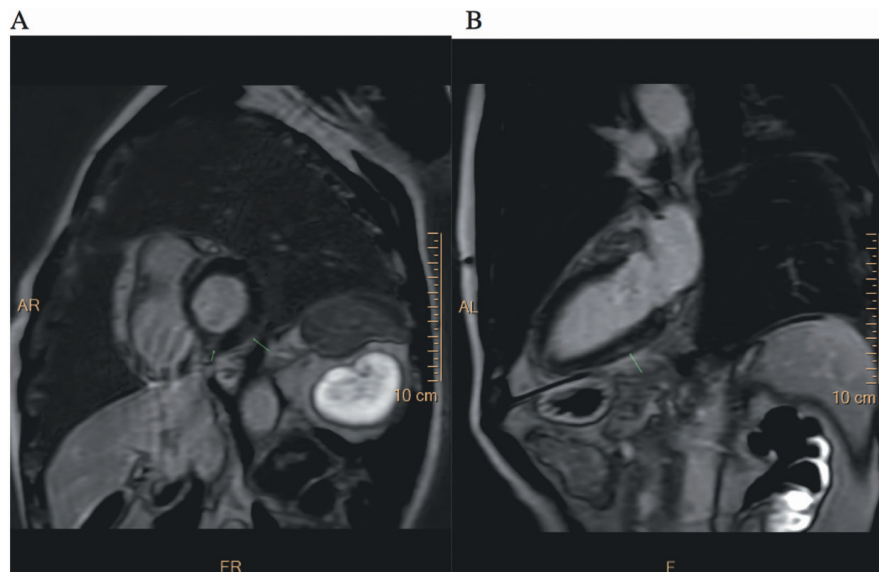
A. Cardiac magnetic resonance imaging short axis view showing patchy areas of the delayed myocardial enhancement of the gadolinium within the left ventricular myocardium. B. Long axis view showing areas of the delayed myocardial enhancement of the gadolinium within subepicardial delayed gadolinium enhancement.
